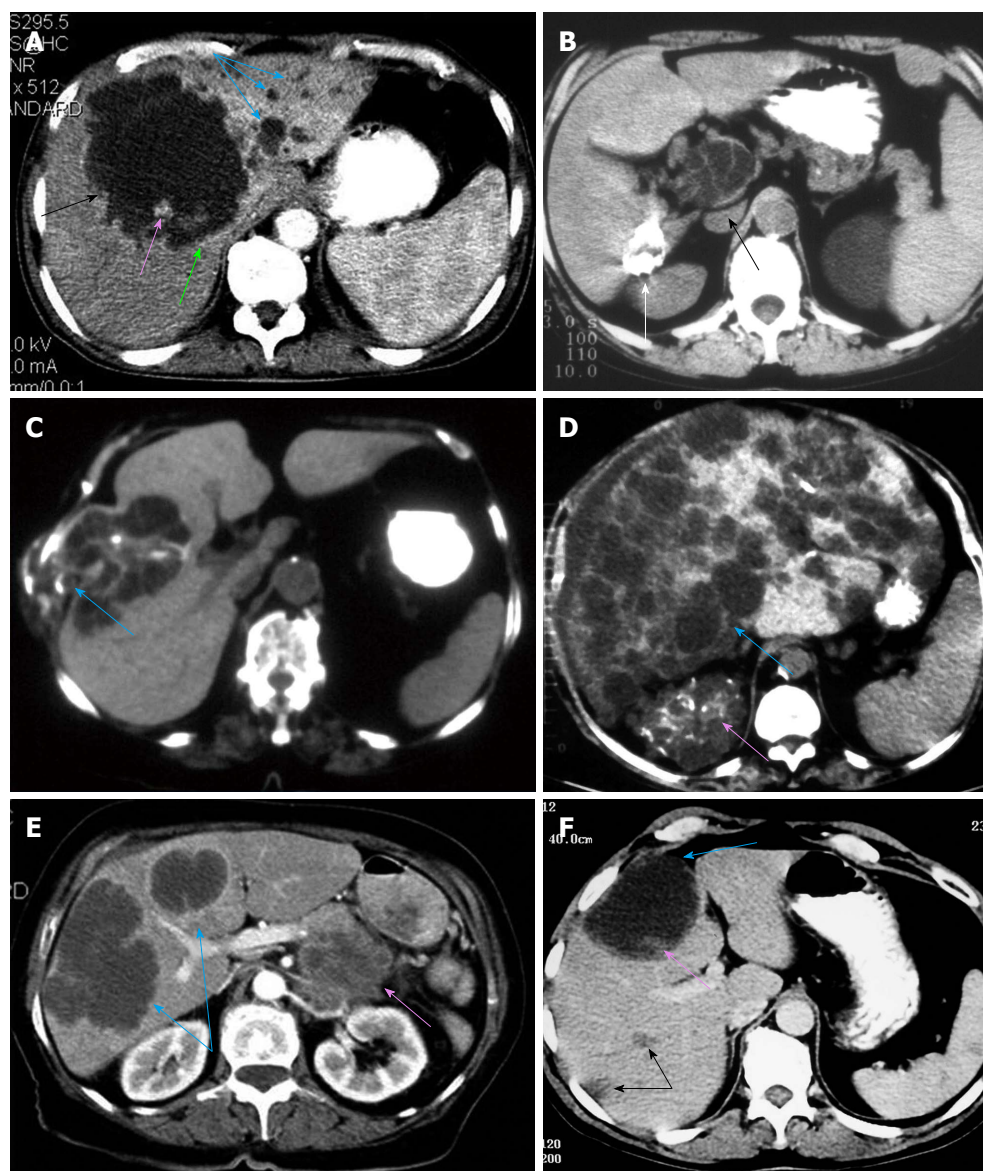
Computed tomography image. A: In liver segment IV there is a large cystic lesion (black arrow) causing compression with dilatation of biliary ducts (light blue arrows) in the left liver lobe. Peripheral contrast enhancement (light green arrow) as well as a nodule (pink arrow) is evident in this case of cystadenoma; B: Echinococcal disease evaluated. Two lesions are evident. The first in liver segment I appears as a multilocular cystic lesion (black arrow) and the second in liver segment VI as a calcified mass with irregular margins (white arrow); C: Demonstrates direct infiltration of a liver hydatid cyst in the adjacent peritoneal surface and abdominal wall (light blue arrow); D: A typical case of multicystic disease with liver (light blue arrow) and kidney (pink arrow) involvement were very well depicted; E: Showing two large cystic-appearing liver lesions (light blue arrows) in a case of a metastatic pancreatic cystadenocarcinoma that is also evident (pink arrow); F: A large cystic lesion (light blue arrow) with a small solid component at the periphery (pink arrow), as well as two small hypodense liver lesions (black arrows), are seen on this image, in a case of proven gastrointestinal stromal tumors metastatic lesions.
